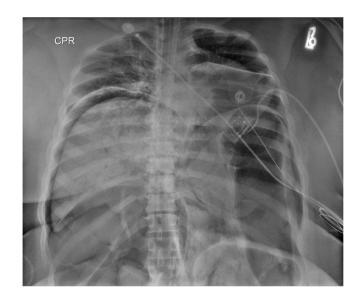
Bedside anteroposterior chest radiograph displaying distended loops of bowel and pneumoperitoneum. Lung volumes are severely reduced as a result of abdominal distension. The presence of air in the hepatic ducts is also noted. The "CPR" annotation in the upper left corner of the figure indicates the radiograph was obtained in the cardiopulmonary resuscitation (CPR) room of the emergency department
